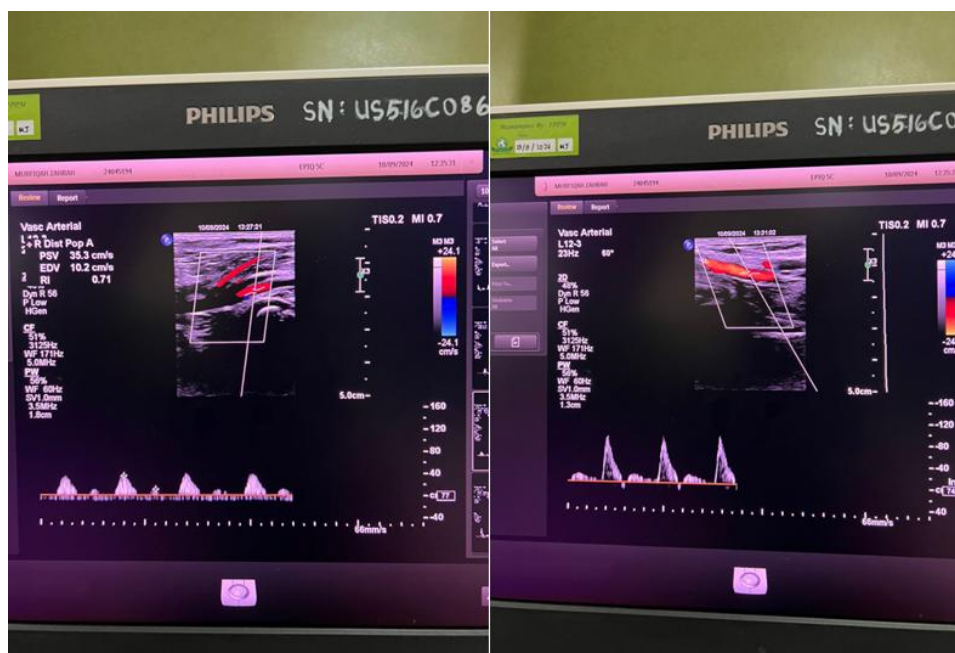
Duplex Sonography Vascular examination results
